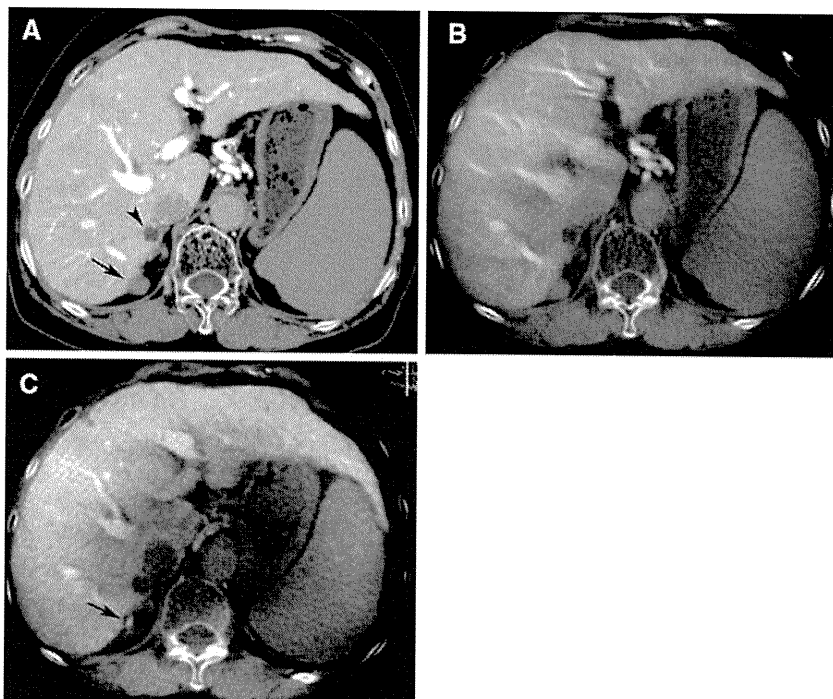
A 68-year-old woman with HCC in the right lobe of the liver. A Conventional CTAP image shows a tumor (*arrow*) and cyst (*arrowhead*) in the right lobe of the liver. B CBCTAP image obtained using a prototype of XperCT software shows both lesions, but artifacts from the portal branches are also seen. C CBCTAP image obtained five months later using commercially available XperCT software shows that artifacts from the portal branches are improved although the image becomes slightly coarse. The size of the tumor also shrinks due to the effect of previous TACE (*arrow*).
